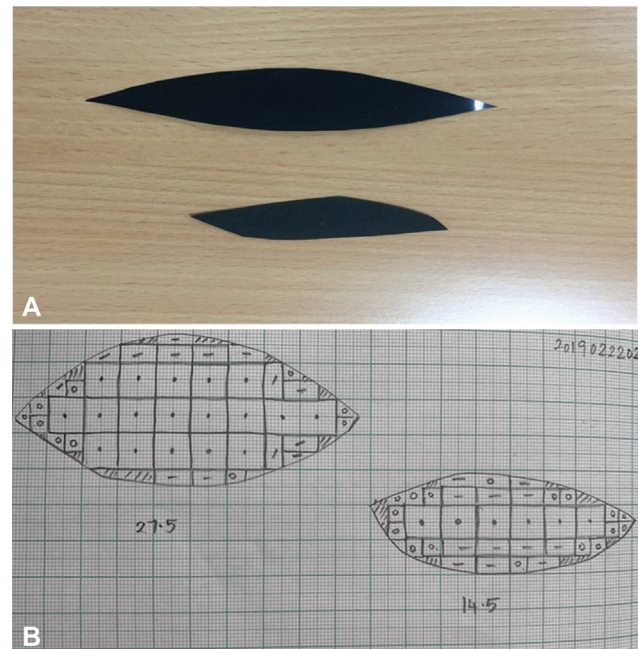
(A) X-ray template of pre- and post-contracted graft tracings. (B) Pre- and post-contracted graft tracings of X-ray templates over graph paper.
